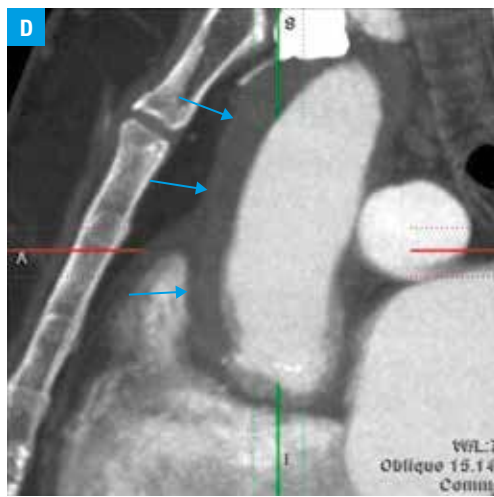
D, E – aneurysm of the ascending aorta, aortic arch, and descending and abdominal aorta, with involvement of kidney arteries (computed tomography); F – aneurysm of the ascending aorta and aortic arch (computed tomography, 3-dimensional reconstruction)
